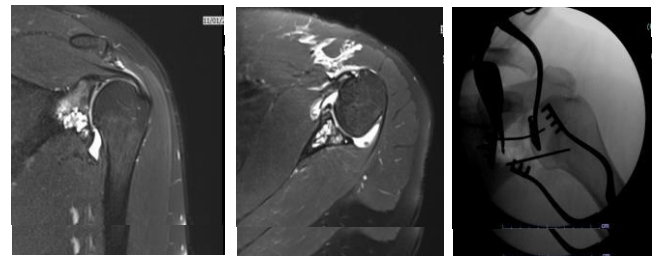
A & B) MRI left shoulder, c) 2 k wires show upper and lower border of glenoid defect intraoperatively
